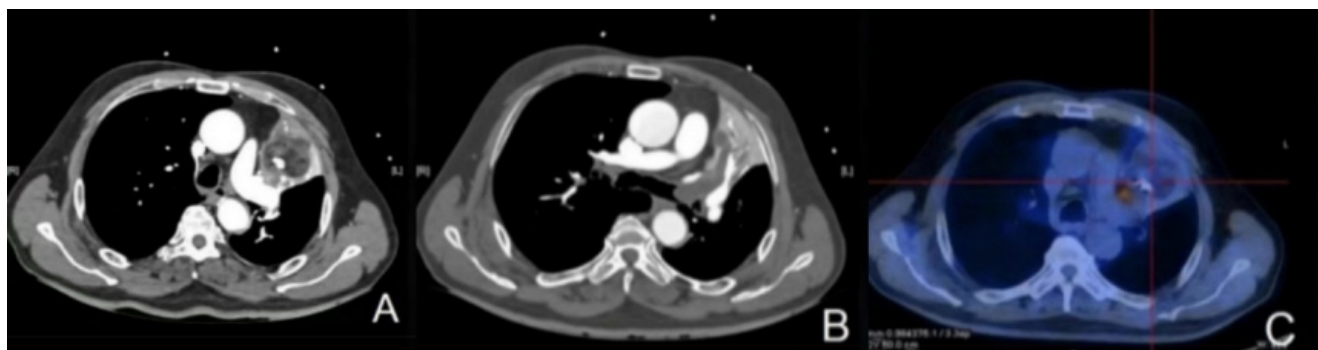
A 72-year-old male presented with complaints of shortness of breath for 2 weeks. Contrast-enhanced computed tomography of the chest (A and B) revealed an irregularly shaped, mixed-density mass with multiple components of soft tissue density, nodular calcification, and some areas of very low density (-51 H to -89 Hounsfield units), suggesting fat in the superior lobe of the left lung, involving the left main bronchus and left superior lobular bronchus, resulting in atelectasis of the left superior lobe. Positron emission tomography/computed tomography [PET/CT(C)] showed most of the mass to be non-fluorodeoxyglucose uptake, with hypermetabolic foci in the lateral portion with a maximum standardized uptake value of 6.2. PET/CT showed no distant metastases or other lesions.
